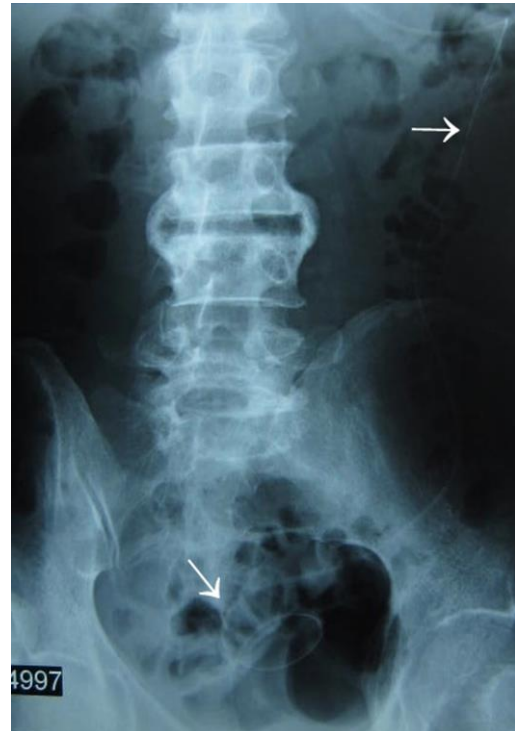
Abdominal x-ray film of peritoneal catheter entering the descendent colon.
